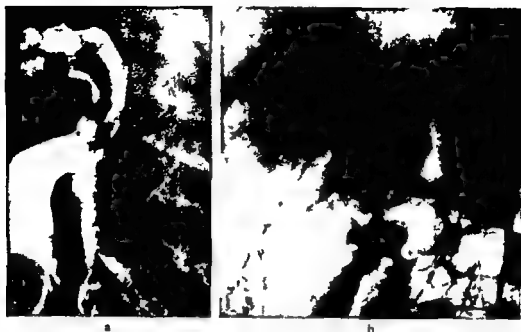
Case 3 59 year-old woman treated for pulmonary tuberculosis 15 years previously. Mild recurrent gastrointestinal hemorrhages had been present for several years. Radiographic control of the pulmonary condition revealed an arteriovenous fistula in the apex of the left lung. a) Pulmonary and b) celiac angiography. a) Subtraction film. Dilated pulmonary artery and 2 draining veins connected by an aneurysmal sac. b) Dilated and tortuous hepatic arteries and irregular accumulation of contrast medium in the liver parenchyma. The hepatic veins filled as in Case 1.
